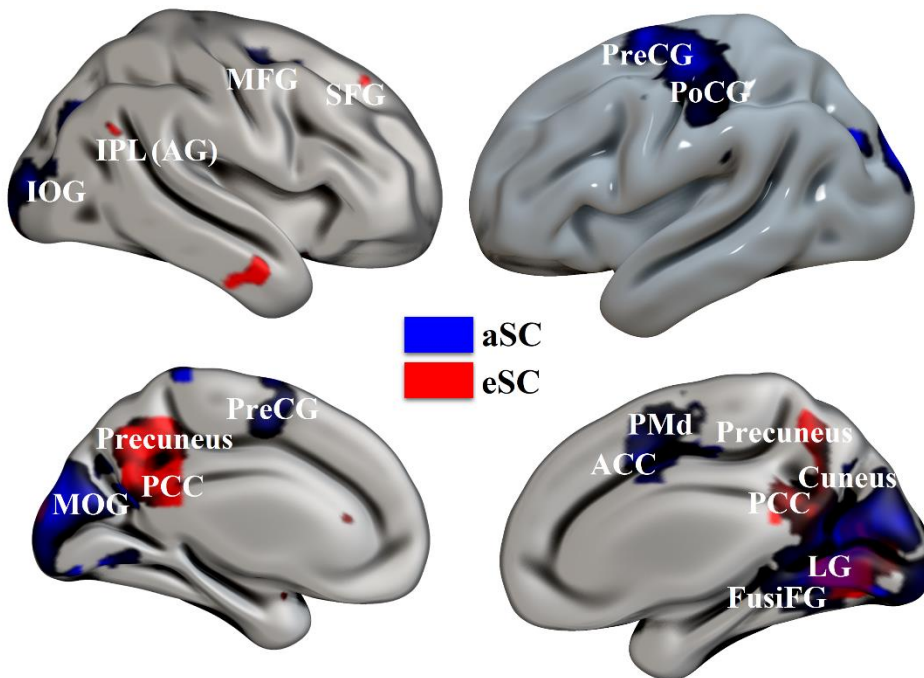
5. Whole-brain functional MRI analyses on aSC_{valid} > NEU and eSC_{valid} > NEU contrasts among younger subjects. Activations blobs are corrected for multiple comparison using $P_{FWE} < .05$. Colour labels blue = allocentric spatial coding and red = egocentric spatial coding. Right and left medial, and posterior three-dimensional views of a standard brain are shown. IOG = inferior occipital gyrus. MOG = middle occipital gyrus. PCC = posterior cingulate cortex. LG = lingual
